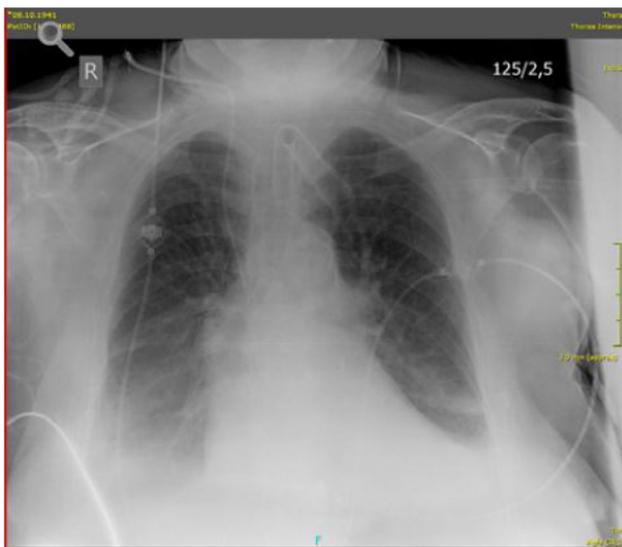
Chest X-ray at end of CytoSorb® therapy
